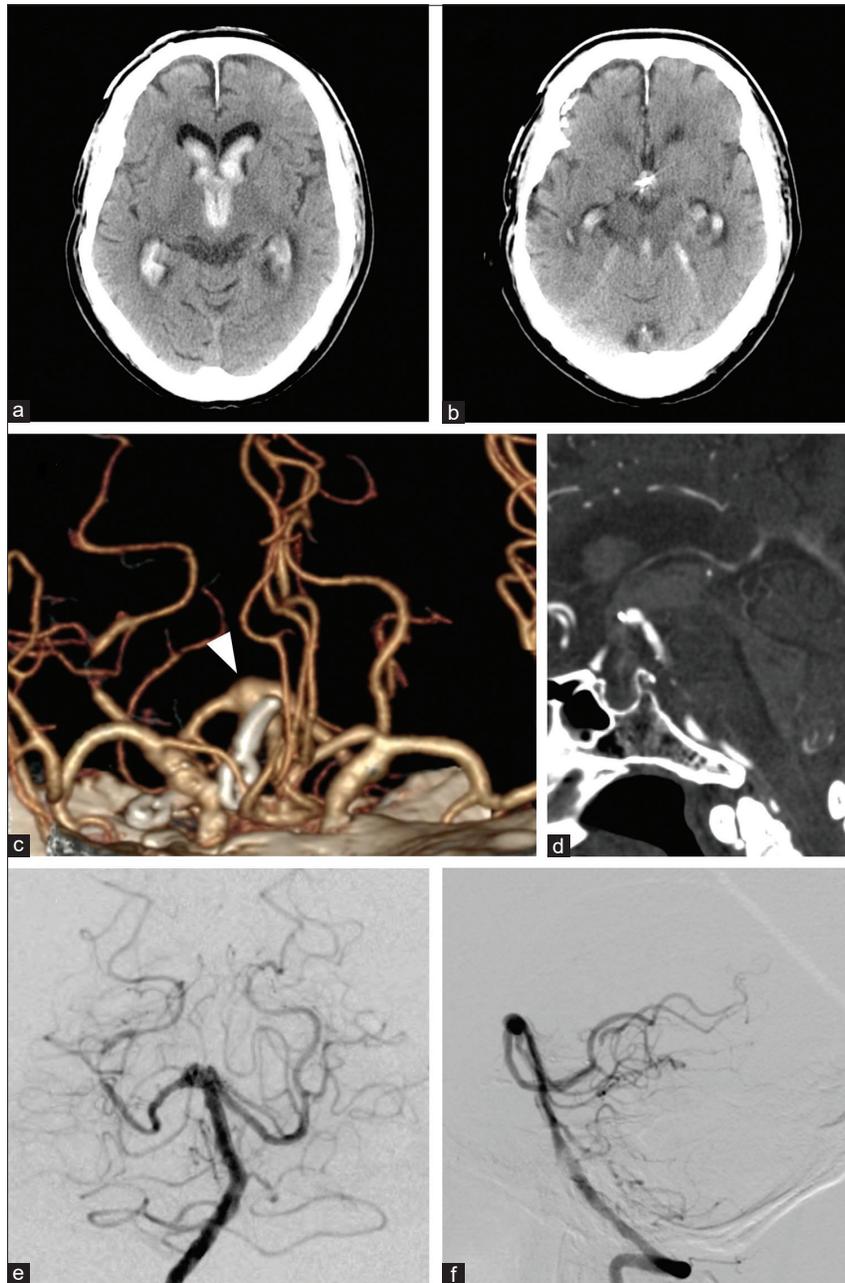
Preoperative images. (a and b) Computed tomography (CT) showing a clot in the third ventricle surrounding the previously applied clip; (c) three-dimensional (3D) CT angiogram showing a tiny bulge on the right side of the previously applied clip (arrow); (d) sagittal view of the 3D CT angiogram showing the distance between the basilar tip and the posterior clinoid process: 15 mm; (e and f) preoperative digital subtraction angiogram showing a tiny bulge on the right side of the previously applied clip and no other bleeding source.
